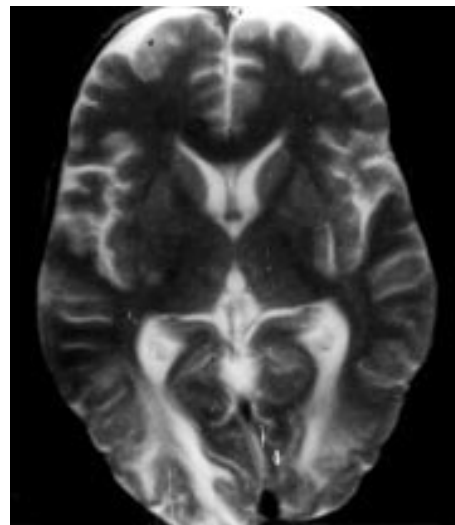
T2-weighted MRI scan showing hyperintensity in the both occipital regions (see case report).
